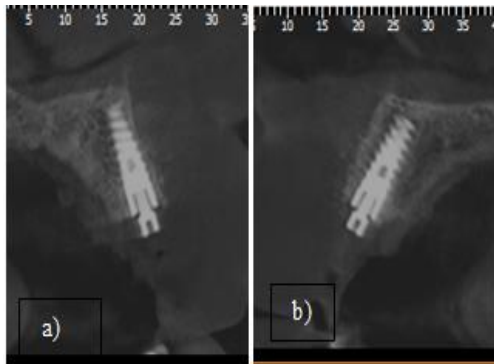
Sagittal Cut of the CBCT a) 1.2, b) 2.1.
